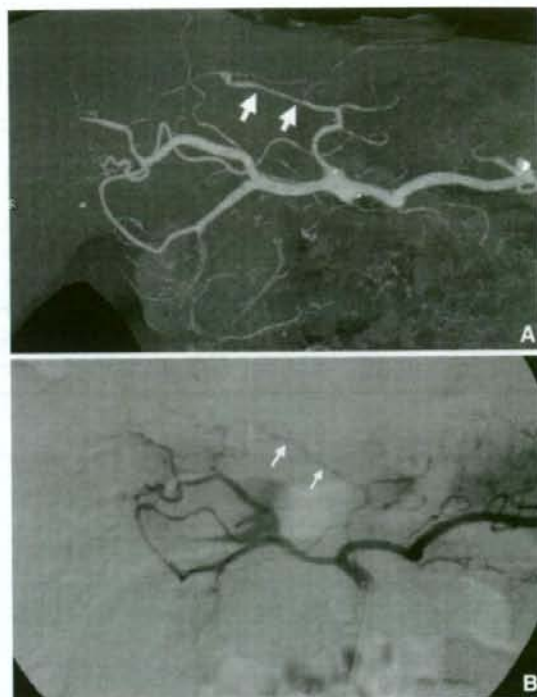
Replaced left hepatic artery in a 73-year-old man with liver metastases. A MSCTA shows the left hepatic artery originating from the left gastric artery (arrows). B DSA of the celiac trunk confirms the CT findings
